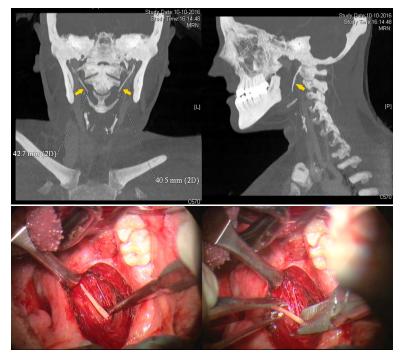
A computed tomography showed elongation of the styloid processes: 42.7 mm long on the right side and 40.5 mm on the left side. Figure 2: Eagle's syndrome was diagnosed and patient underwent transoral surgical approach to remove both styloid processes.
